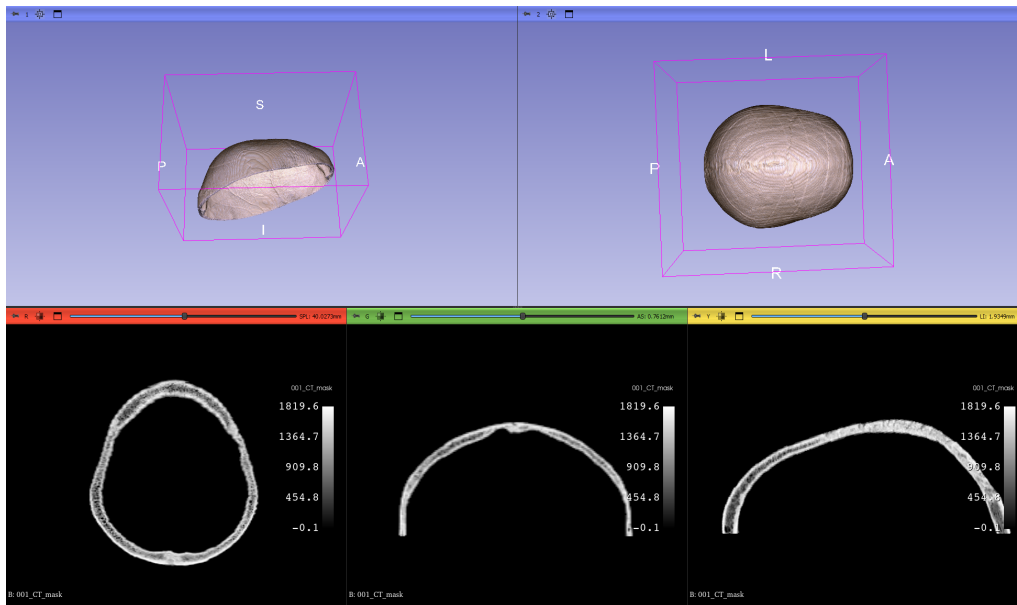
An example of the created 3D calvaria volume of one CT image on the upper part of the Figure. Distal, dorsal, and medial views in the lower part, respectively.
